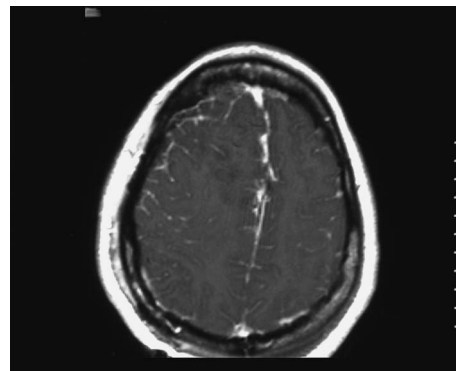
Postoperative T1 weighted magnetic resonance image with gadolinium for case 3.
